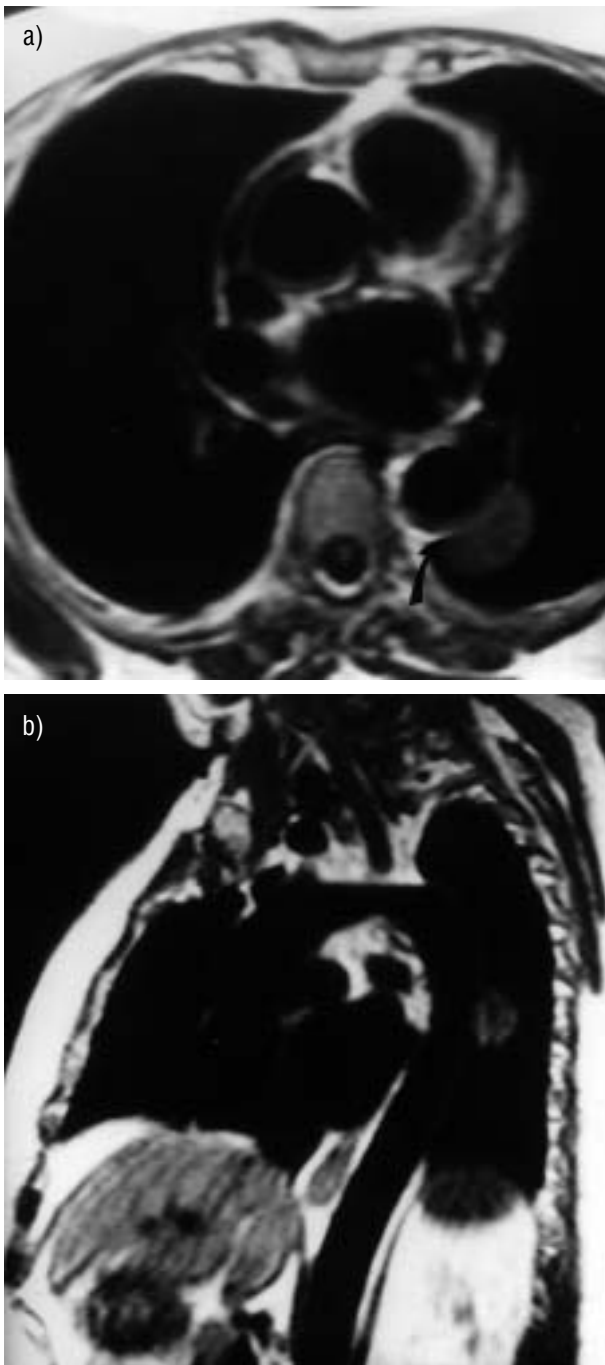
T1-weighted images demonstrating superior ability of magnetic resonance imaging in demonstrating loss of fat plane (arrow) in a) axial and b) sagittal planes.
